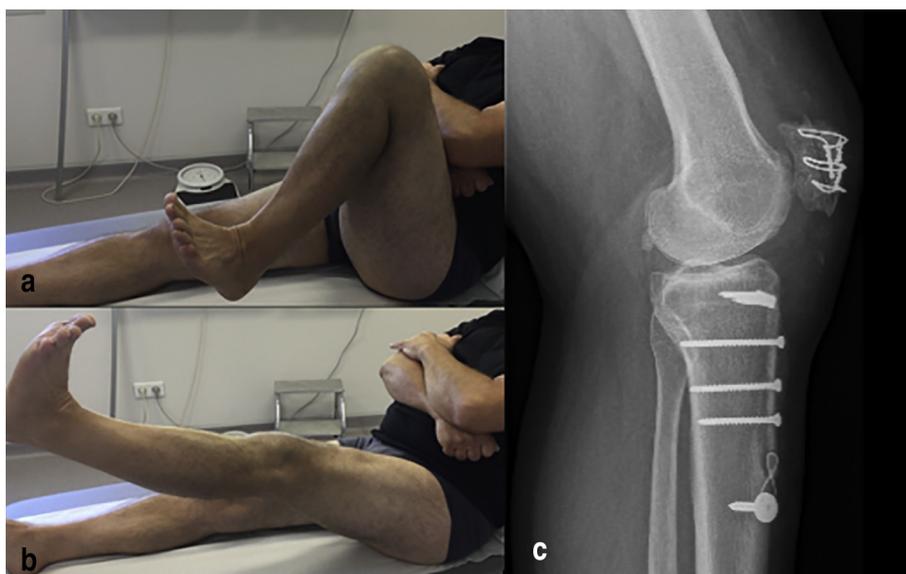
Clinical and radiologic outcome at 24 months of follow-up: a & b: Excellent clinical result with 130° of flexion and no extensor lag. c. Lateral view radiograph at 24 months of follow-up: we can note the bone healing and the absence of secondary migration. The CDI was normalised at 1.
